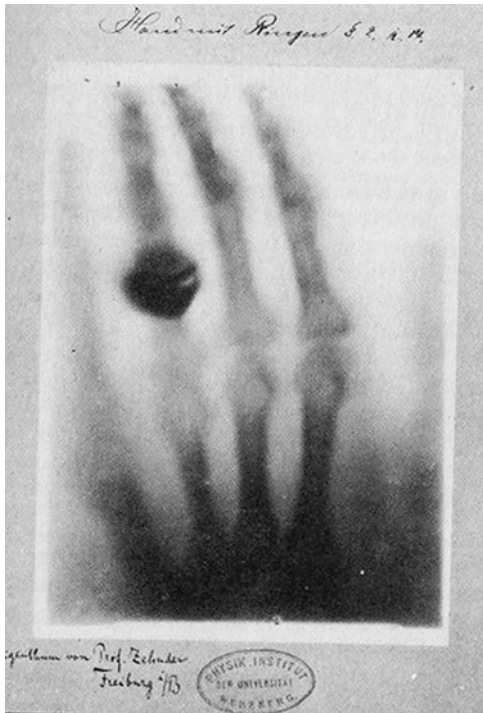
The hand X-ray of Konrad Roentgen's wife [8]
